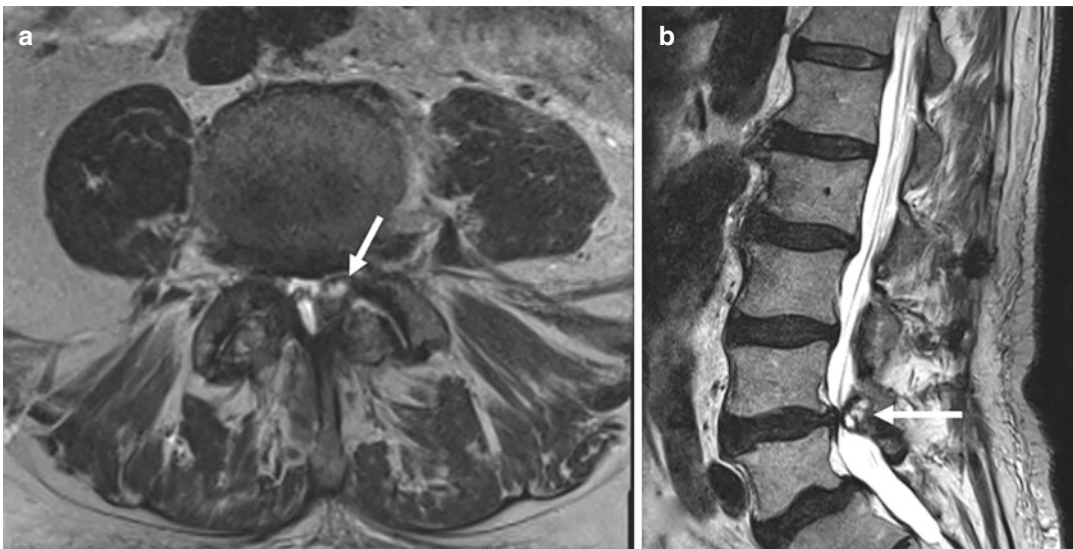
Synovial cyst. (a) Axial T2-weighted MRI of the lumbar spine shows a cystic lesion (arrow) extending anteromedially from the left degenerated facet joint. This synovial cyst impinges on the left subarticular zone.
